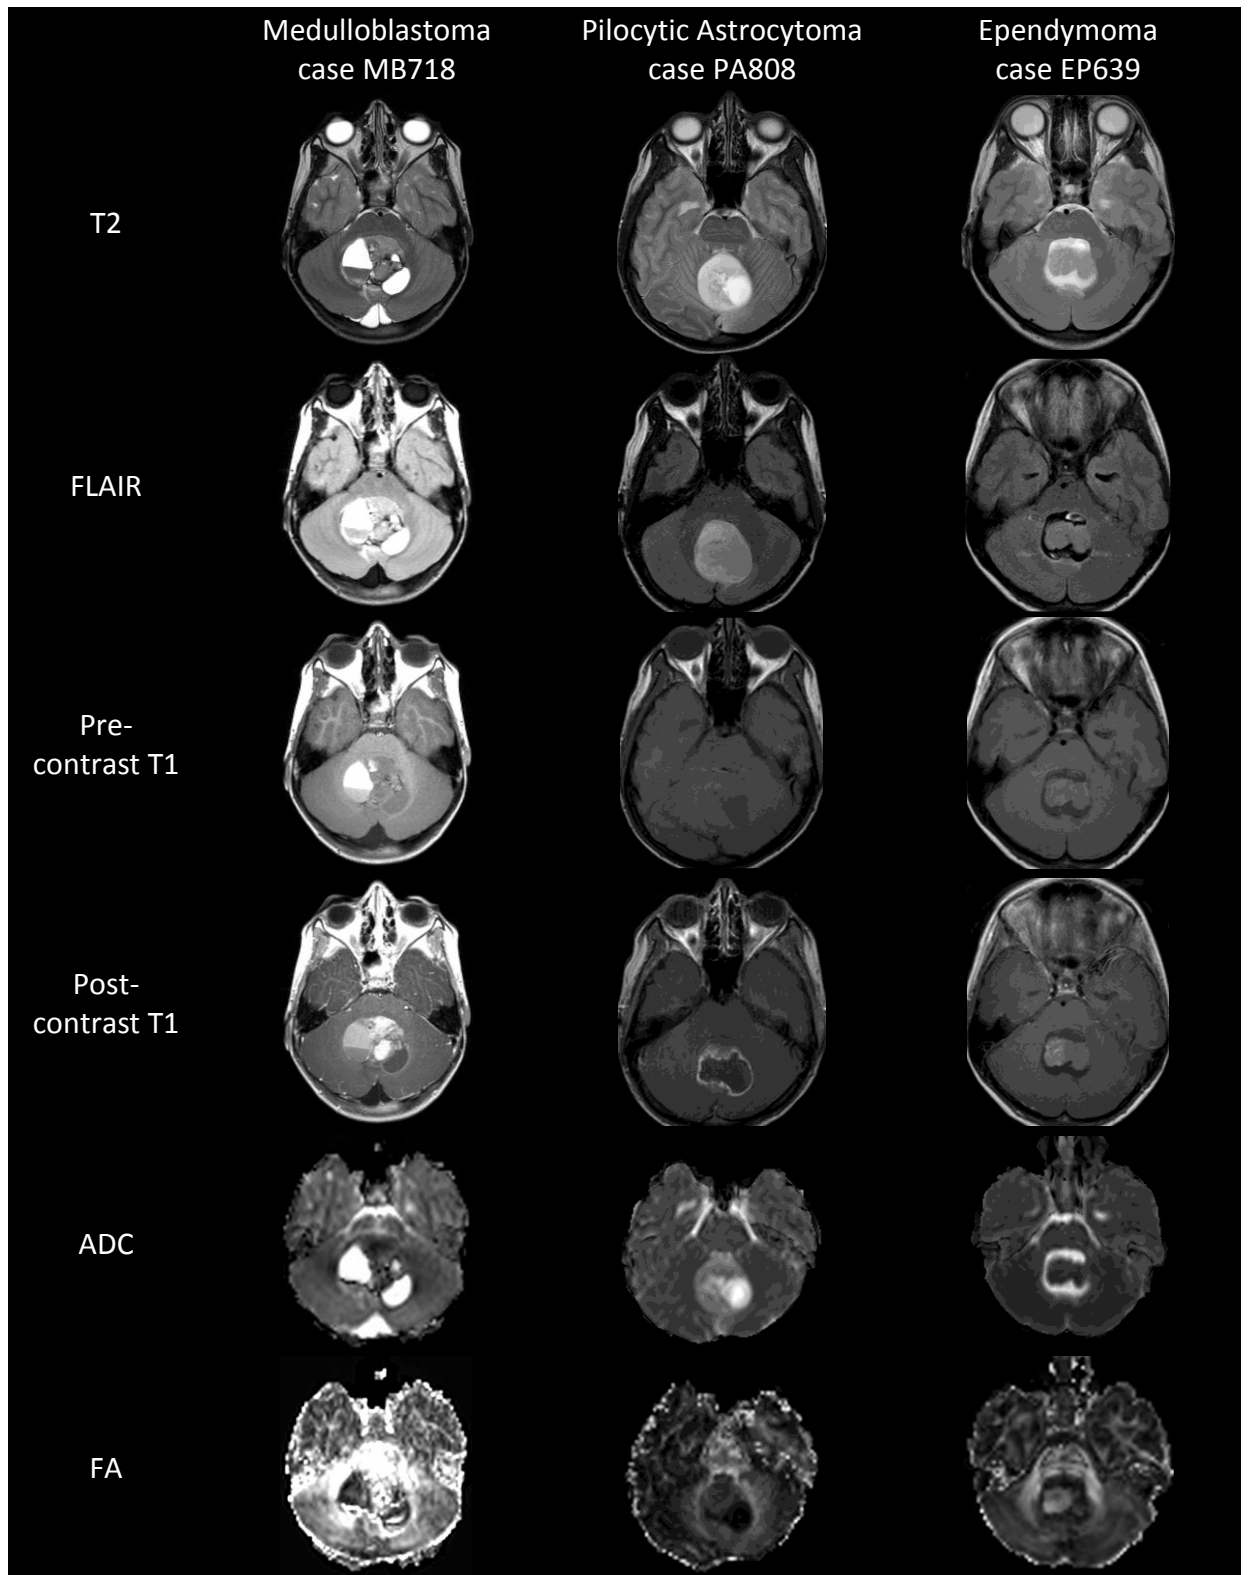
Difficulty in differentiating the three tumour types. Imaging features of medulloblastoma, pilocytic astrocytoma and ependymoma are shown based on conventional and diffusion MRI.
